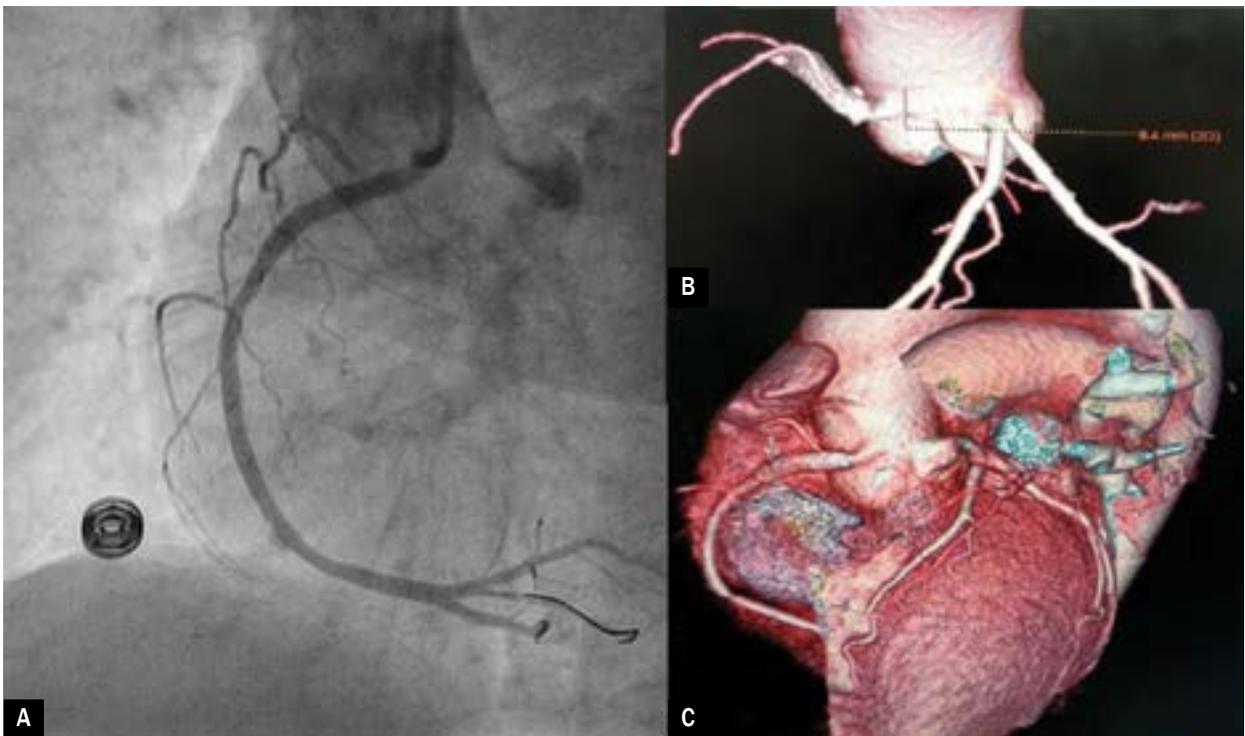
Right coronary artery showing TIMI III flow with well deployed stent (A). Multidetector computed tomography (MDCT) showing ectopically arising right coronary artery (RCA) with high take-off (B, C)
